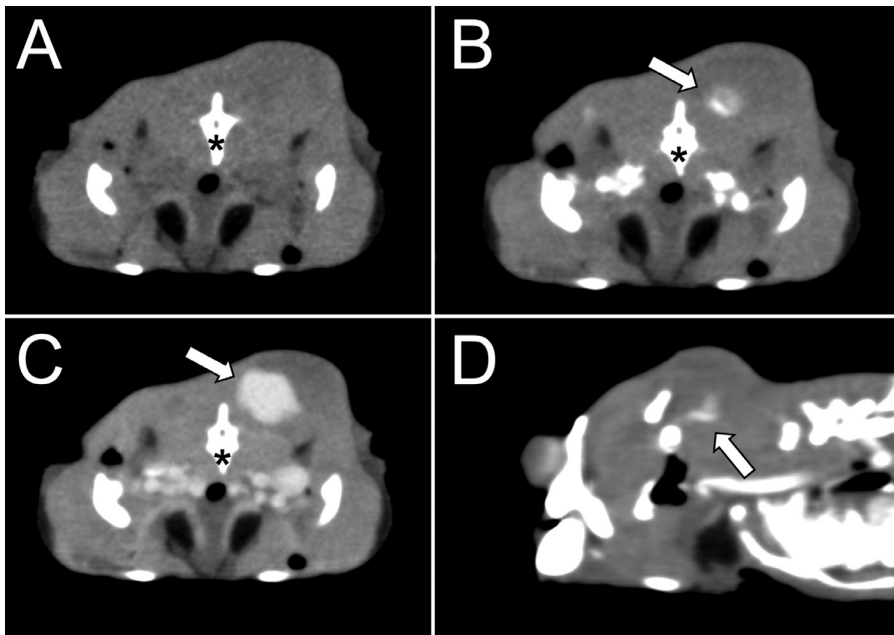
A through C—Transverse CT images acquired in a soft tissue window before contrast, 10 seconds after contrast, and 300 seconds after contrast, respectively. These 3 images were acquired at the level of the C2 vertebra (asterisk). The right of the patient is to the left of the image. There is a bulge of the left dorsal temporo-orbital region. There is a faint ovoid, fluid-attenuating (54 HU) mass in this region. Notice the progressive increase of contrast (arrow) within the mass. D—A parasagittal oblique image acquired at 10 seconds after contrast. The head is facing to the left of the image. A small amount of contrast is identified extending from caudal to the paraoccipital process of the otooccipital bone into the mass.
